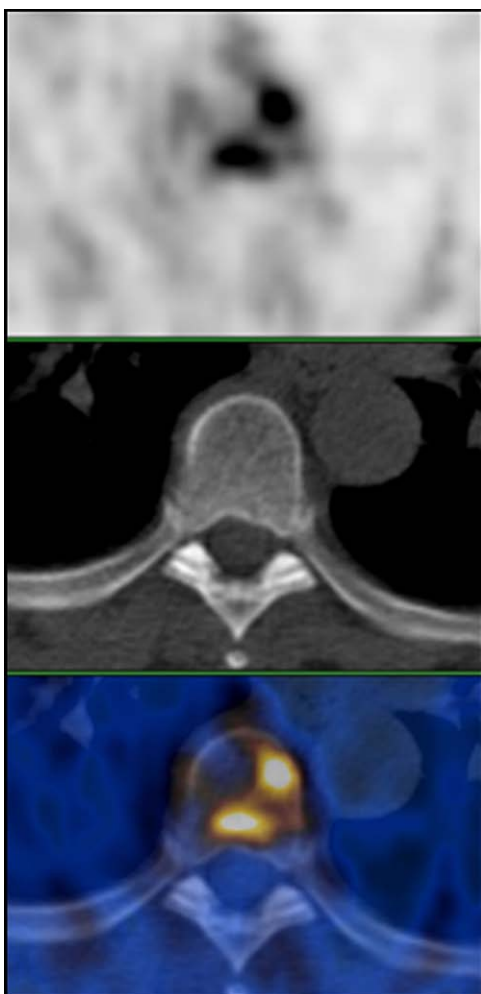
Bone marrow metastases in the thoracic spine detected by FCH PET/CT in preoperative evaluation of a high-risk prostate cancer patient.
